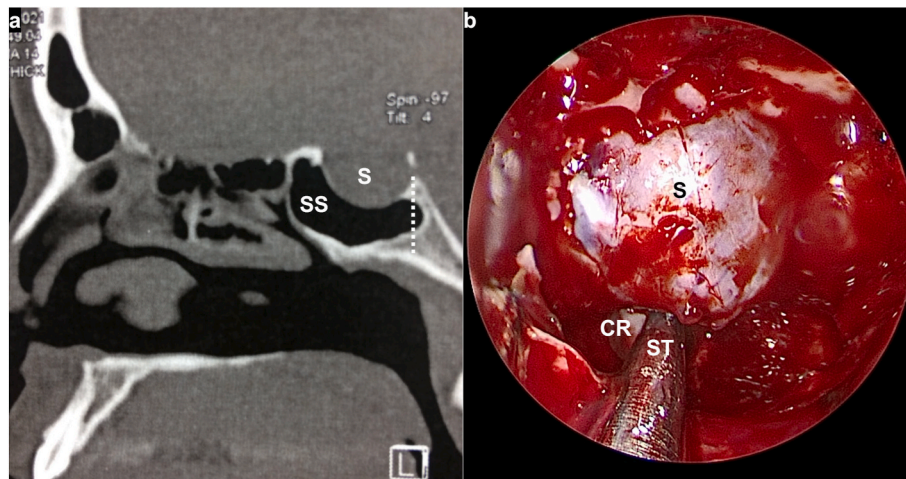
The clival recess (a) Computed tomography scan of the paranasal sinuses sagittal view showing a sellar type of the sphenoid sinus, the clival recess is represented by the pneumatized sphenoid sinus posterior to the posterior border of the sella (dotted line), (b) endoscopic endonasal view inside the sphenoid sinus of the same patient in (a) using a 0° angle scope. The bony sellar floor has been opened. A suction tube without a side channel can be seen anchored within the clival recess and partially supported superiorly by posterior margin of the bony sellar floor. CR: clival recess; S: sella; SS: sphenoid sinus; ST: suction tip.
